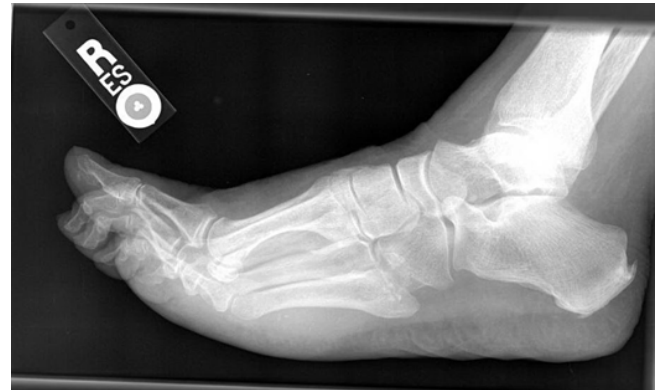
X-ray lateral view right foot.
